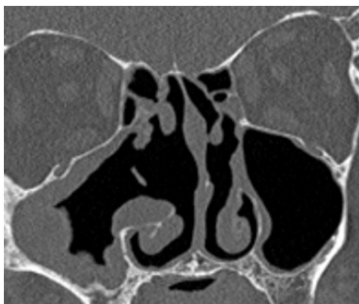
The control CT scan one week after the surgical intervention. A single cavity of the maxillary sinus and an ethmoid labyrinth on the right.
